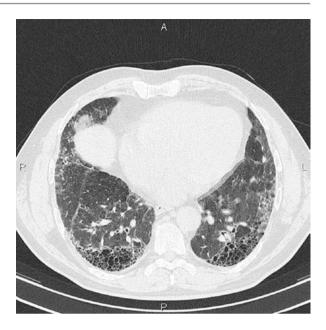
HRCT of the lungs: UIP—the sign of honeycombing, distorsion of lung parenchyma and a reduction of volume of both lower lung lobes (interlobar fissure shift)
